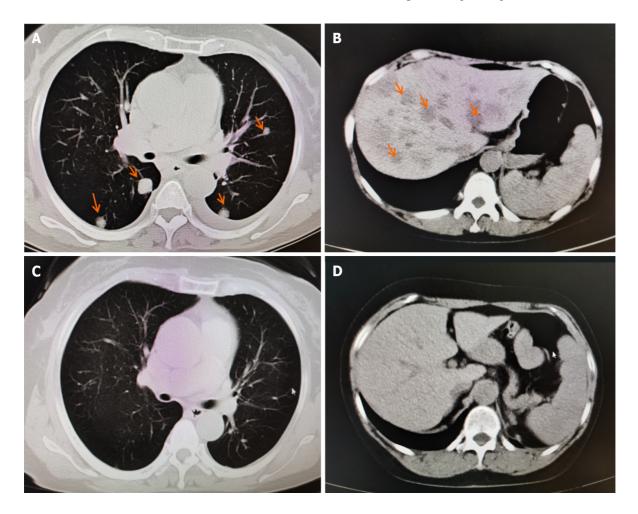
Contrast of the patient's chest computed tomography. A and B: Chest computed tomography (CT) in April 2020 before administration of antiprogrammed cell death-1 (PD-1) therapy. The orange arrows indicate metastases; C and D: Chest CT in January 2021, 9 months after initiation of anti-PD-1 therapy. The metastases have disappeared.
